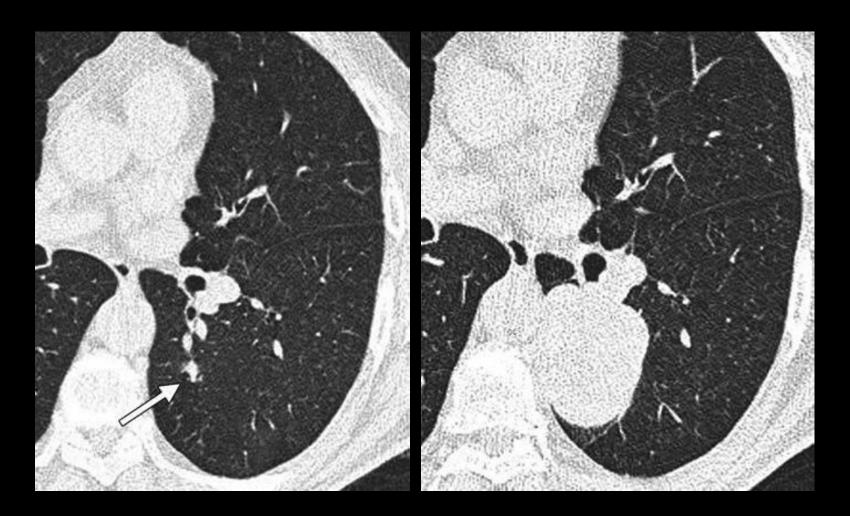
Subsolid nodule, demonstrating worrisome change. (A) An annual CT, demonstrating a persistent 14-mm pure GGO (arrow). This is a Lung Reporting and Data System (LU-RADS) 4B nodule (likely low-grade adenocarcinoma). The patient was not referred to surgery and did not return for recommended follow-up. (B) CT 3 years later, showing the nodule has enlarged to 34 mm and contains a 12 mm solid portion. The nodule is now classified as LU-RADS 4C (likely malignant).
